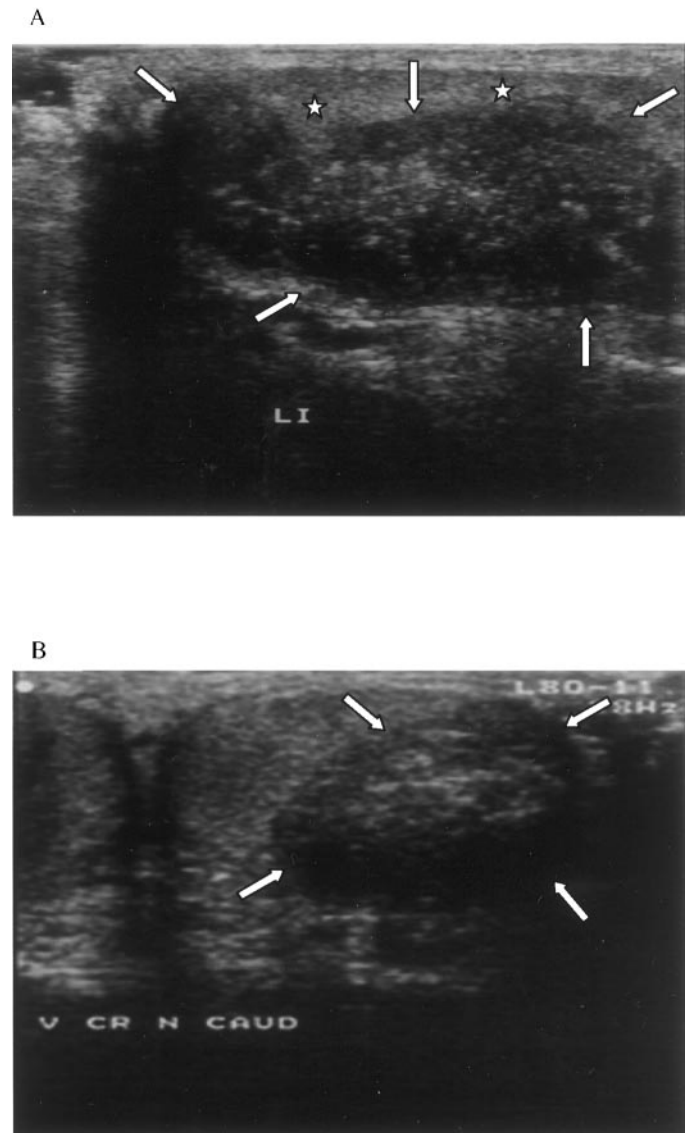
Large palpable adrenal rest tumor in a 17.3-yr-old male patient (no. 5) with 21-hydroxylase deficiency. A, Longitudinal ultrasonographic image of the left testis showing a well delineated mass with marked irregular echo texture (*arrows*). Note that only a small rim of normal testicular tissue is visible (*stars*). B, Ultrasonographic image obtained in the transverse plane. The tumor measured $3.8 \times 3.8 \times 2.0$ cm.
